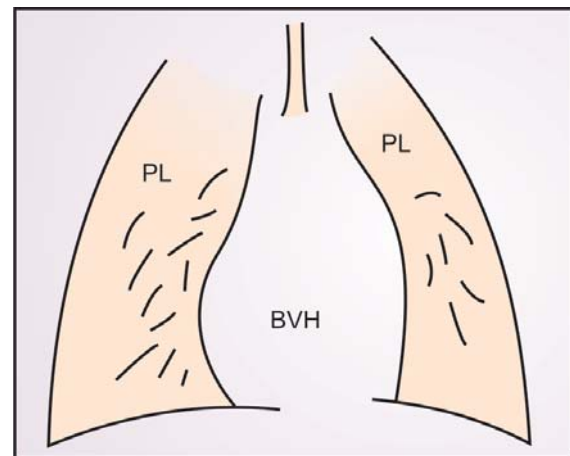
Classical X-ray appearance of a large VSD
